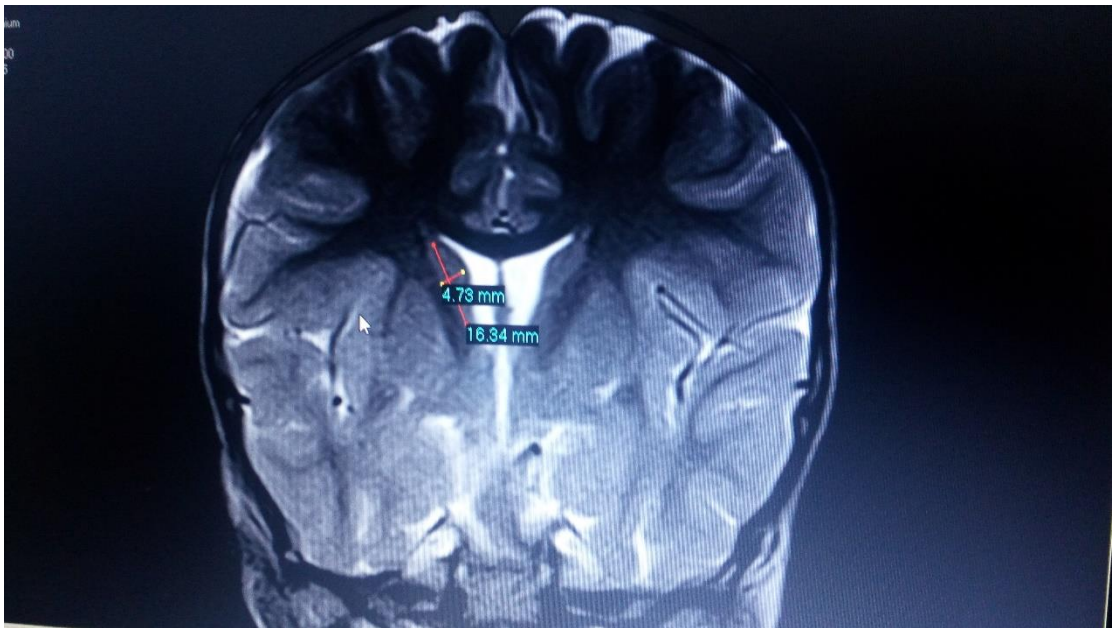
Coronal T2 MRI Brain (head of caudate nucleus)
